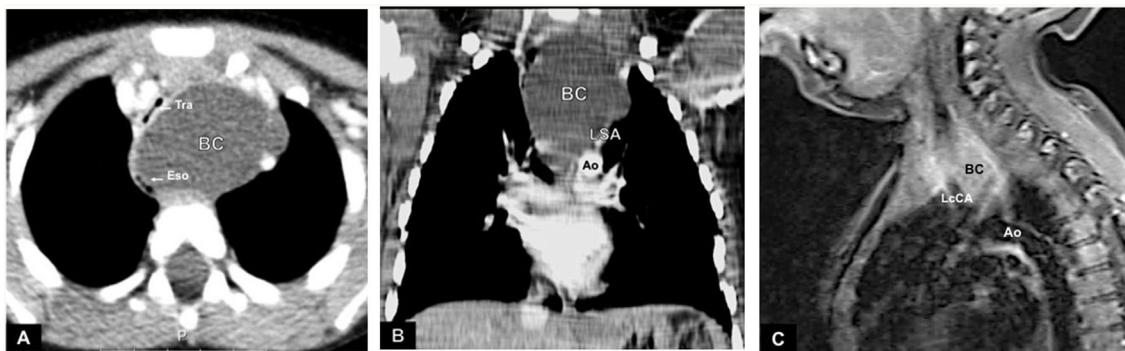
(A, B) Computed tomography scan before drainage; (C) magnetic resonance imaging after drainage.
